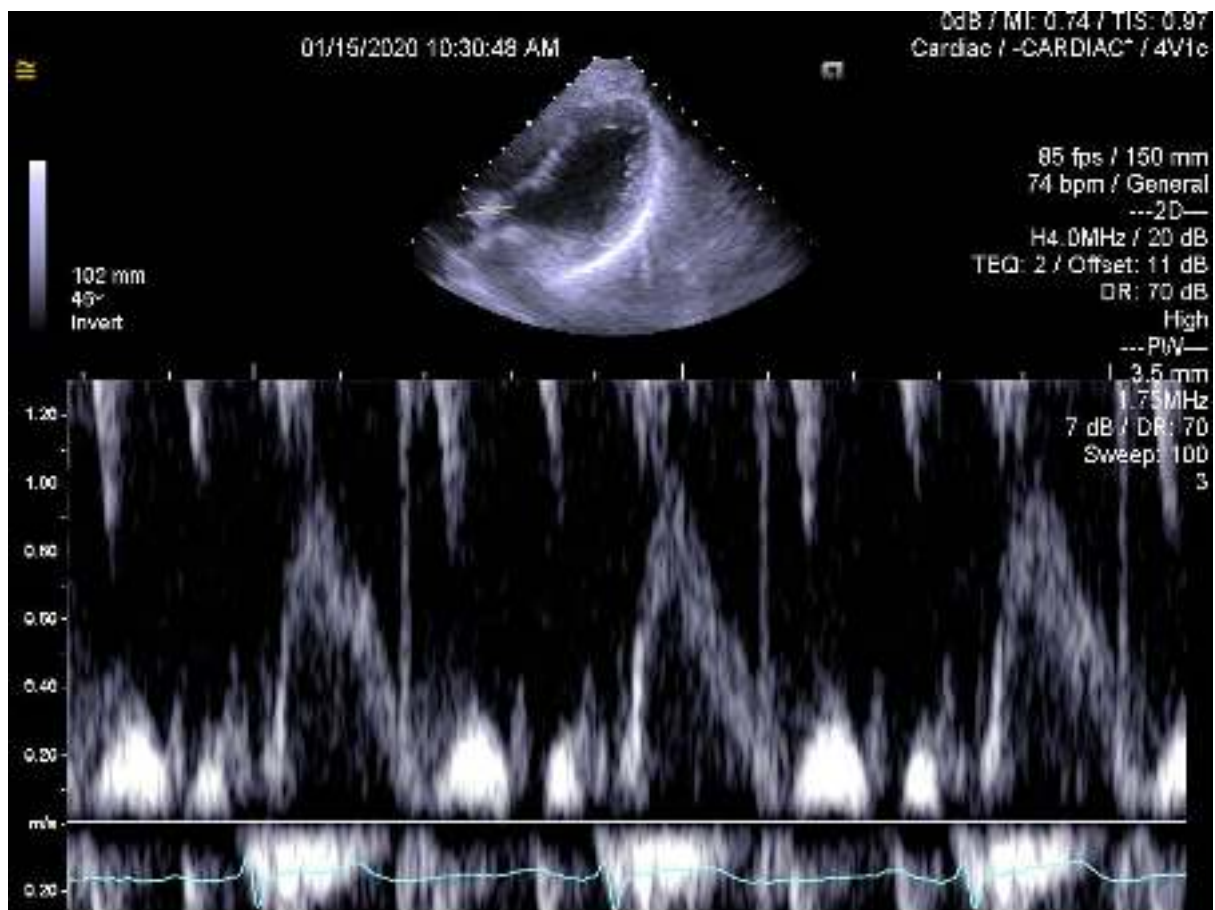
Velocity waveforms in the apical five-chamber view.
